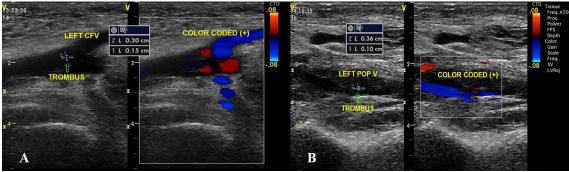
DUS on the third day showed thrombus on (A) left common femoral vein and (B) left popliteal vein. DUS: duplex ultrasonography.
